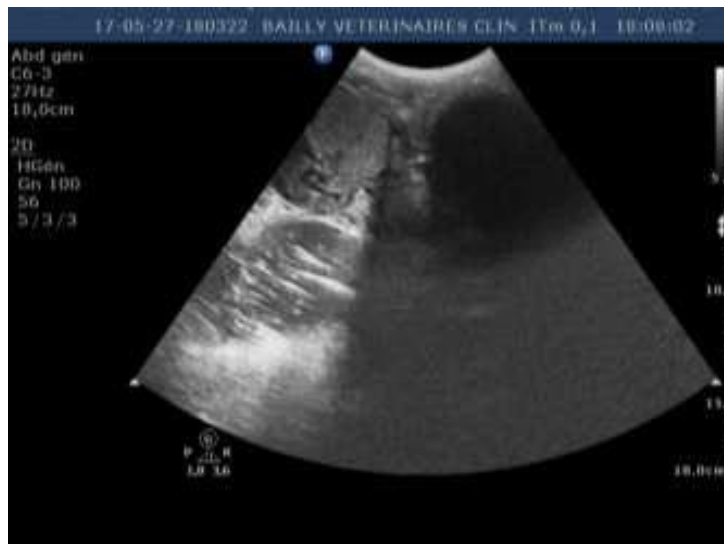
Abdominal ultrasound showing a right inguinoscrotal hernia. HMMI-Meknes Imaging Department
